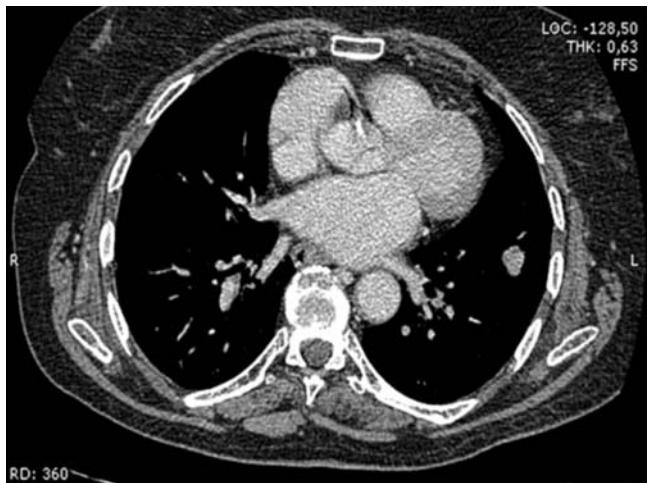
CT scan of chest, mediastinal window. Note same nodular lesion shown in Fig. 30.2 with no pleural attachment.
